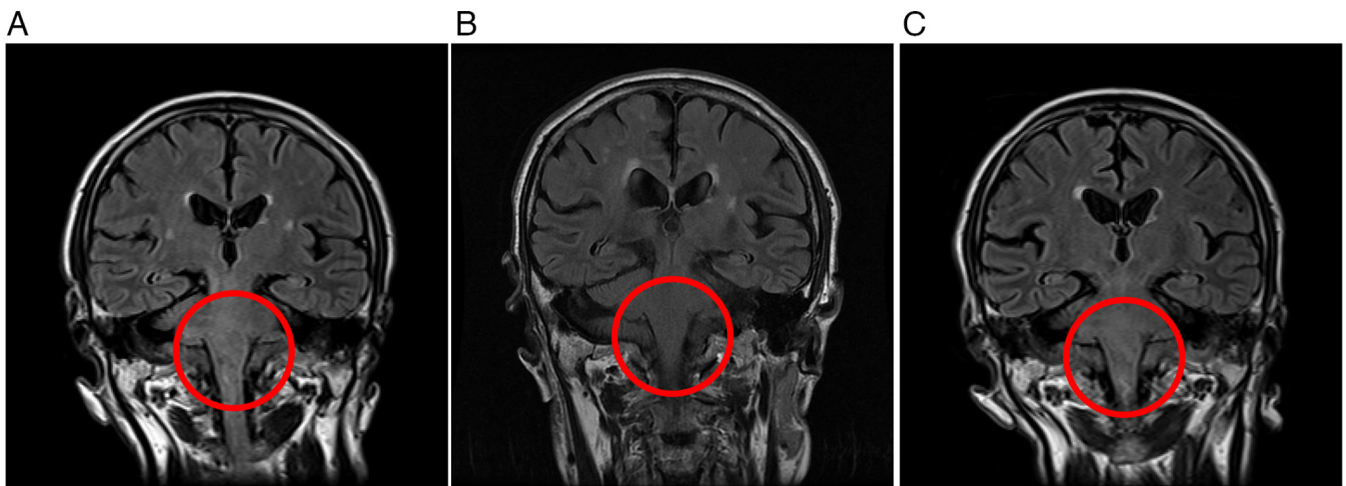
Serial brain coronal fluid-attenuated inversion recovery images of the brain. (A) At initial presentation, hyperintense lesions were observed in the brainstem region. (B) After chemotherapy, complete radiographic resolution of the lesions was confirmed. (C) At second relapse, recurrent hyperintense lesions were detected in the same anatomical region. The red circles indicate the area of interest.
